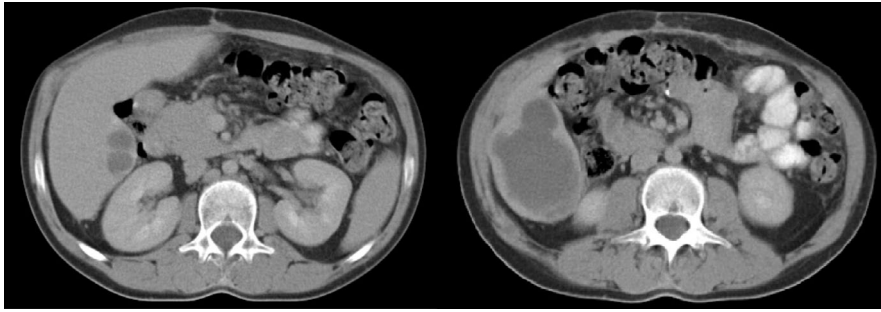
Liver CT. Hypervascular lesion in segments V/VI, hypodense in the central portion, and contrast uptake to the periphery
